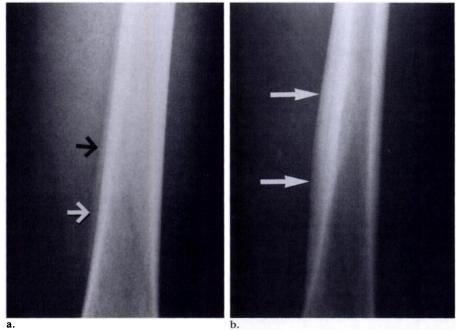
Maturing traumatic periostitis.(a) Anteroposterior radiograph of the femoral shaft shows thick, uninterrupted, unilaminar periosteal new bone (arrows). (b) Anteroposterior radiograph obtained 2½ months later. The periosteal bone (arrows) has matured and is incorporated into the underlying cortex. The patient's symptoms had resolved.
